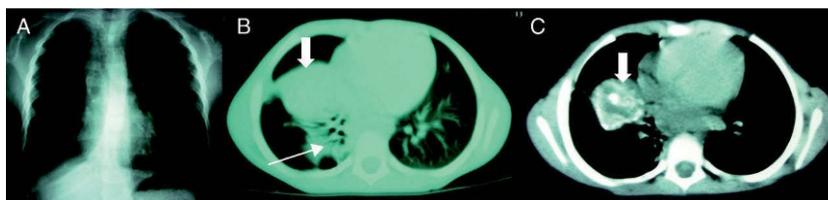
A) Anteroposterior chest x-ray shows a pulmonary consolidation in the middle lobe with right paratracheal widening and an emphysematous lesion in the right hemithorax. B-C) Lung HRCT shows right mediastinal adenopathies (C) and a well-defined, partially-calcified loculated collection with a necrotic appearance (thick arrows), of a large size (3.5 × 4 cm), and adjacent images of pulmonary consolidation with atelectasis in the lower right lobe and middle lobe (thin arrow).
